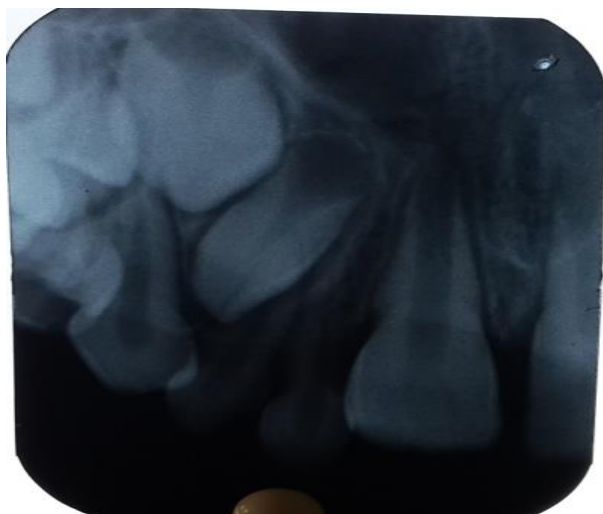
Intraoral periapical radiograph w.r.t 11
